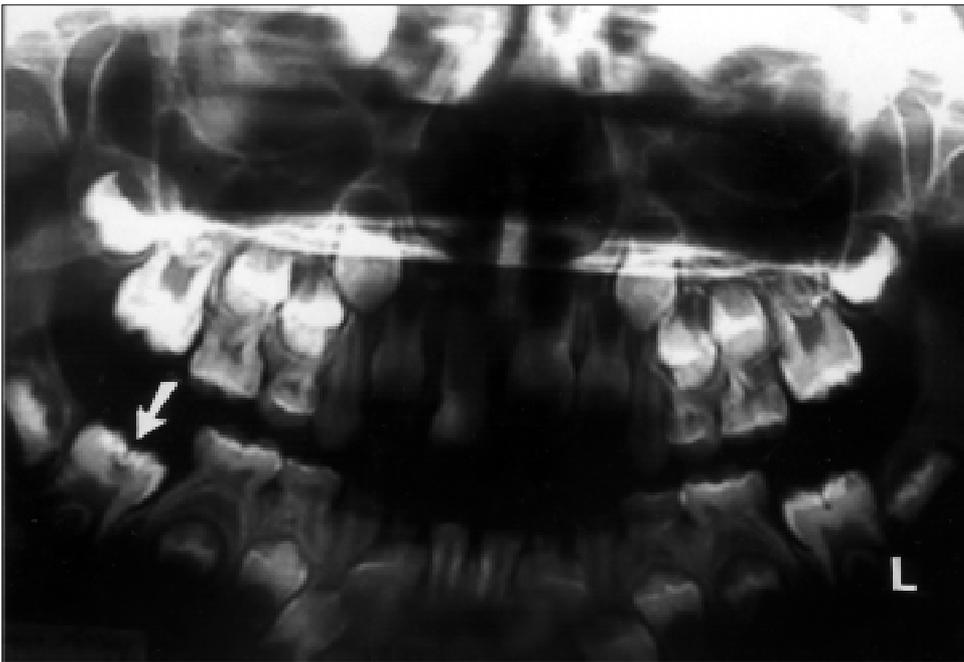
An intracoronaral resorptive defect within the crown of an unerupted mandibular right first permanent molar (arrowed), discovered incidentally on the orthopantomogram.
